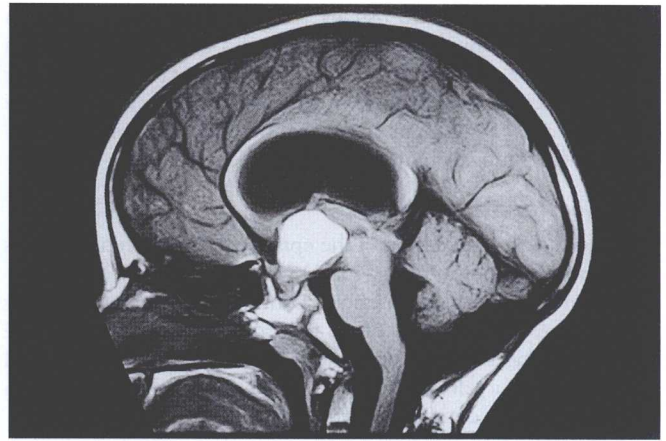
MRI scan, sagittal view. Craniopharyngioma. The mass in the suprasellar cistern is of high signal intensity owing to the proteinaceous fluid that the cyst contains (courtesy of Dr Juliette Britton).
